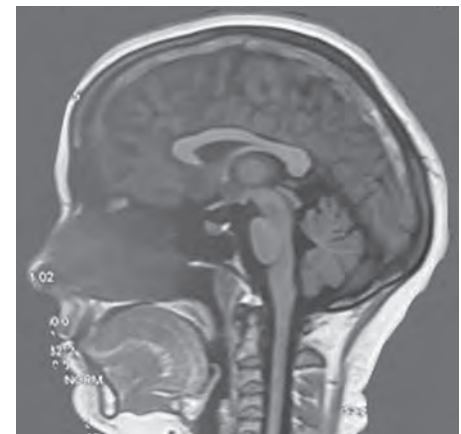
Magnetic resonance imaging (MRI) brain sagittal image showing thrombosis of superior sagittal sinus
